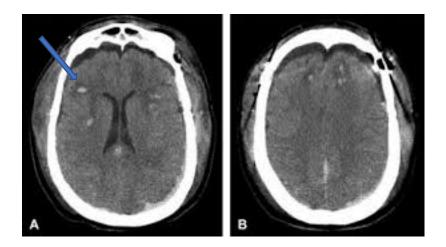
Diffuse axonal injury on head CT. White spots (arrow) in the brain indicate areas where white matter tracts have been torn and bleeding has occurred.
